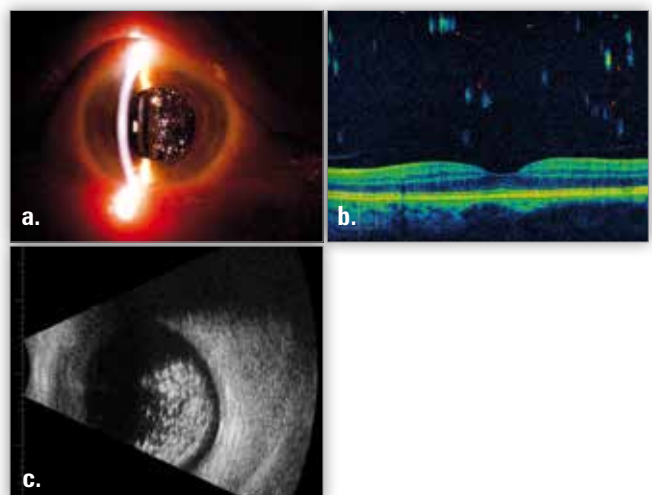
Asteroid hyalosis: color photography of slit lamp examination in a patient with asteroid hyalosis – a., asteroid bodies in OCT (arrows) – b., asteroid bodies in ultrasound – small hyperechogenic echoes within vitreous – c.
